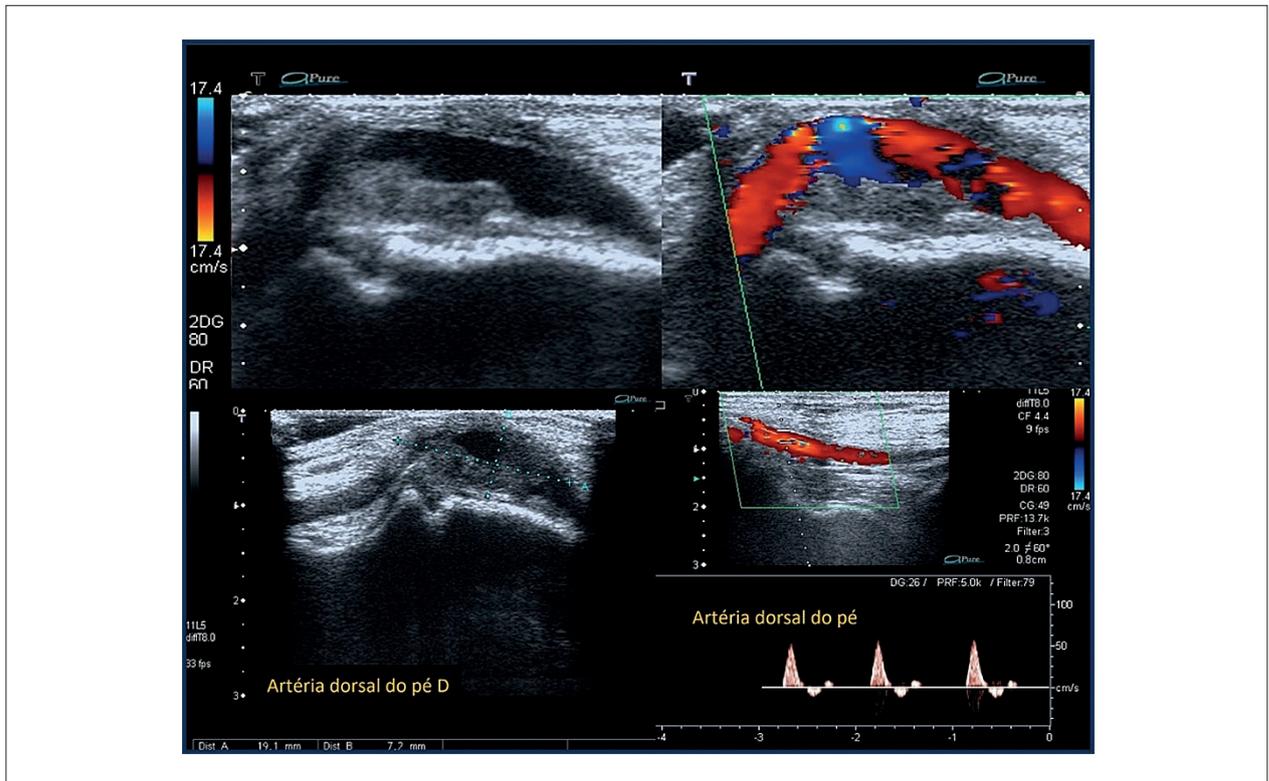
Dorsalis Pedis Artery Aneurysms (DPAA) of the foot. A and B: Two-dimensional and color Doppler ultrasound images demonstrate arterial patency and the presence of thrombi; C: aneurysm measurements; D: Multiphasic flow before dilation on spectral Doppler.
